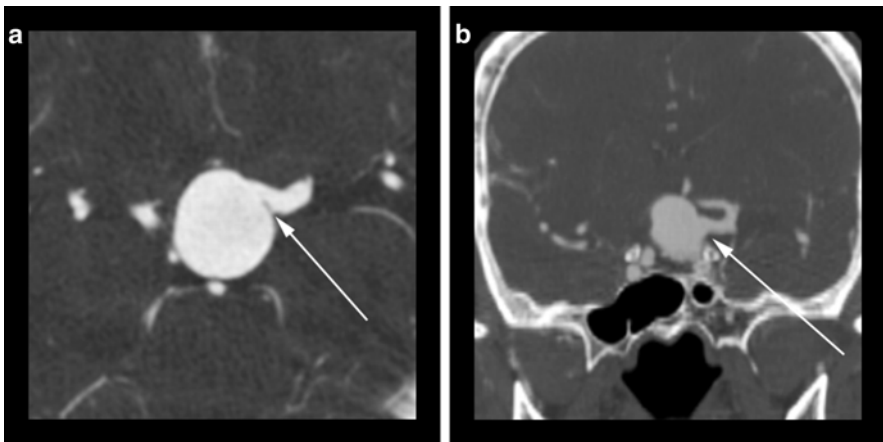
(a) An axial CTA image reveals a giant basilar tip aneurysm with apparent incorporation of the left posterior cerebral artery (*arrow*). (B) A coronal CTA MIP image reveals that the left vertebral artery origin arises (*arrow*) from the middle aspect of the body of the aneurysm which would preclude a traditional coil embolization without protective measures
